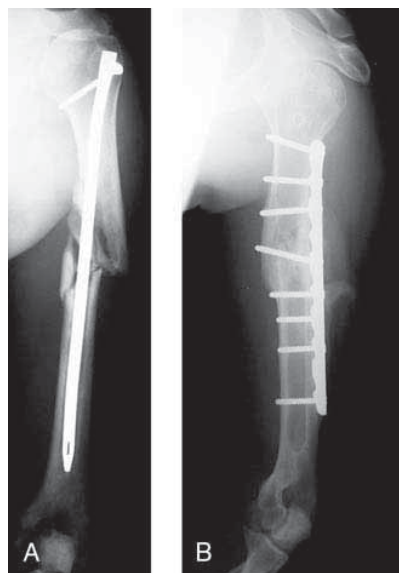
A, AP radiograph of the left humerus of a 35-year-old man made 9 months after intramedullary nail fixation of an open fracture sustained during a fall. The patient reported pain when he used the arm and a sensation of instability and weakness. The radiograph shows a small-diameter nail, locked only proximally; a malaligned fracture; and no evidence of fracture healing. B, The humerus healed well after the fixation was revised to a long, large plate to provide adequate stability and alignment. Excellent bone apposition was achieved, and an autogenous cancellous bone graft was placed around the nonunion site.
